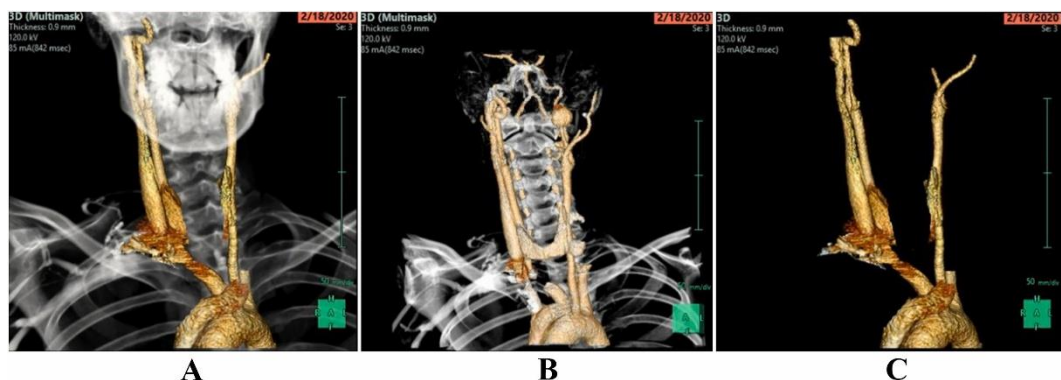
A, 3B, 3C: Contrast-enhanced CT scan Soft Tissue Neck with contrast (Coronal Reconstruction Series) demonstrating 2 cm distal left internal carotid artery pseudoaneurysm.
